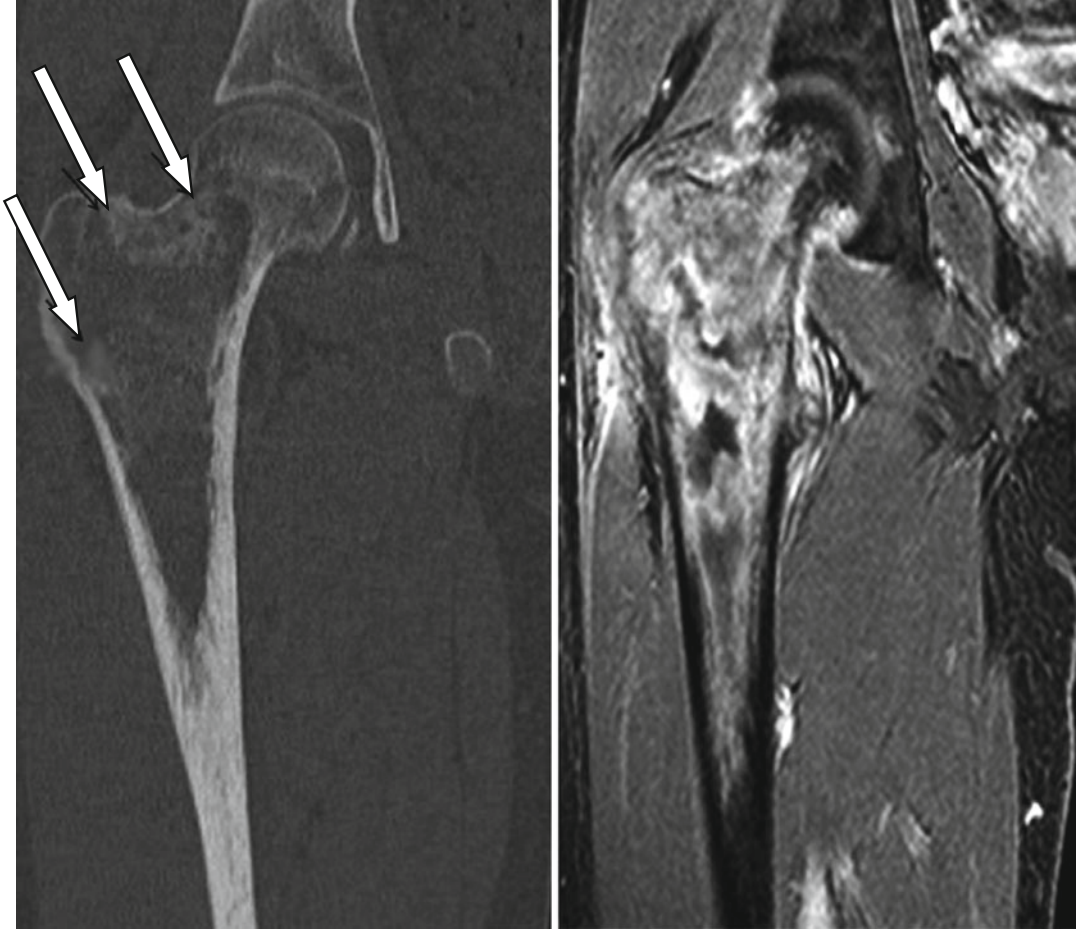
Similar findings with Fig. 21.5 are evident on CT (a coronal MPR) and MRI (b T1-weighted fat-saturated imaged post iv injection of contrast)
